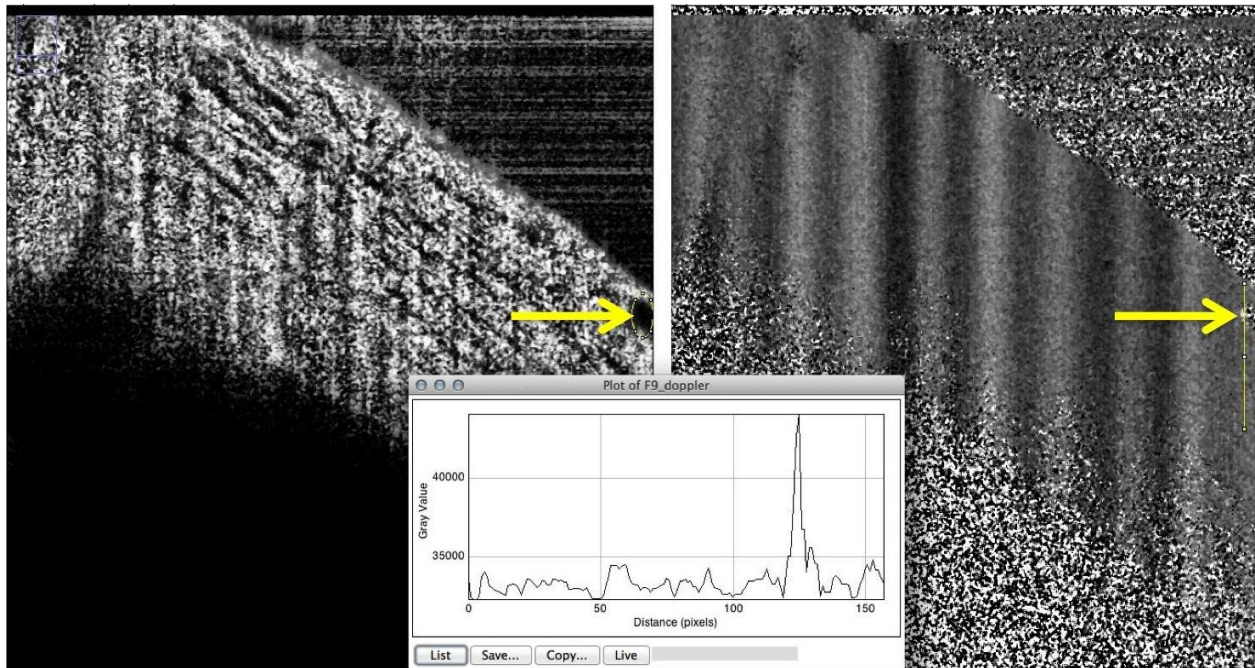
Despite containing a large measurable Doppler signal, this region *may* be noise as suggested by the salt/pepper Doppler pattern.
